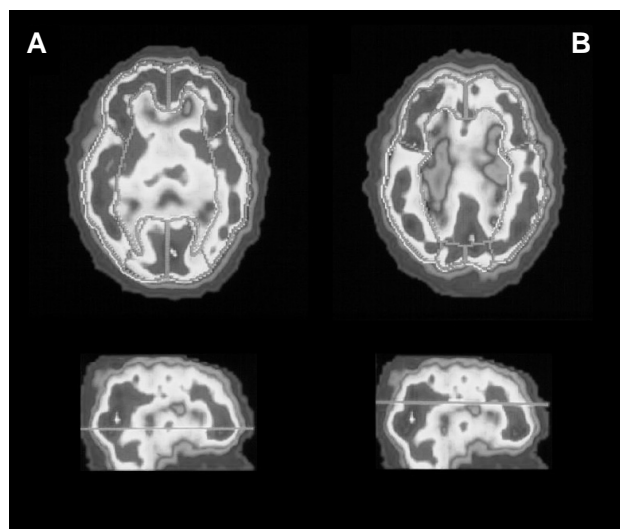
Visual description of the brain regions chosen and the cuts made for the SPECT analysis.
